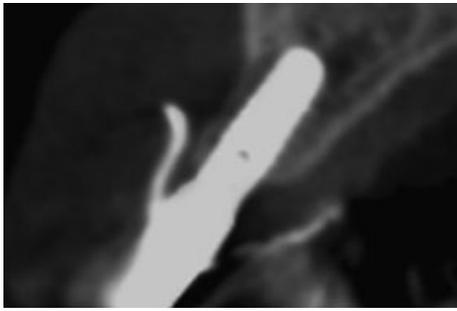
Mid-buccal cross-sectional cone beam computed tomography slice showing the radio-opaque contrast material used for soft-tissue visualization.
